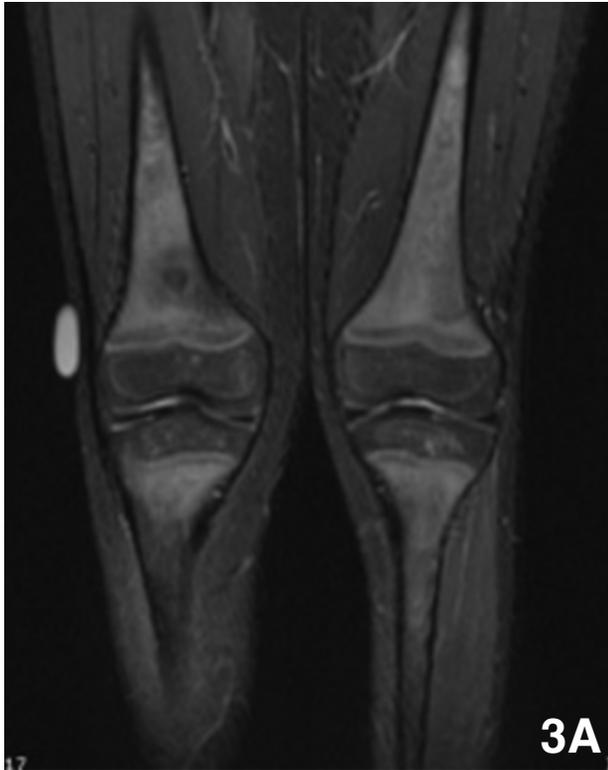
Coronal STIR (TR 4500, TE 40) MR image shows decreased patchy abnormal marrow signal in the distal femora and proximal tibiae.
